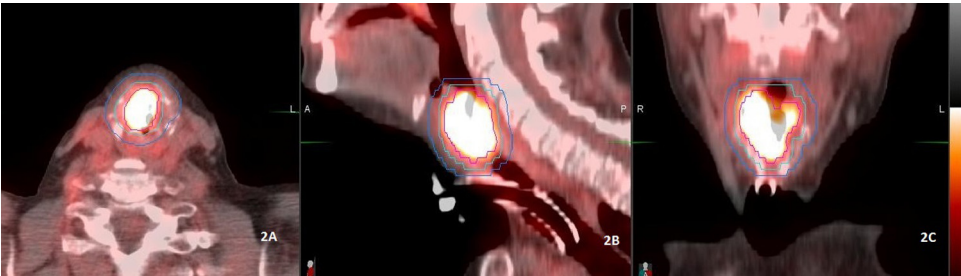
62 year old female, previously irradiated. T3 transglottic laryngeal carcinoma with pathologically proven thyroid cartilage invasion. Axial fused PET/CT (2A) shows the location and extent of the metabolic activity of the tumor. Sagittal and coronal PET/CT images (2B, 2C) show the primary VOI (red) and two outer VOIs (light blue and dark blue).
